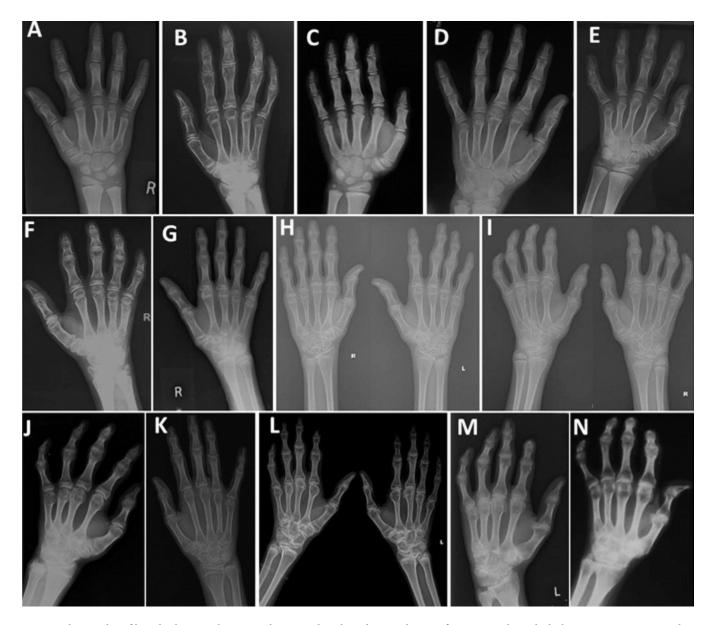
Radiographs of hands showing large epiphyses and widened metaphyses of metacarpals and phalanges. Joint space is also reduced.
